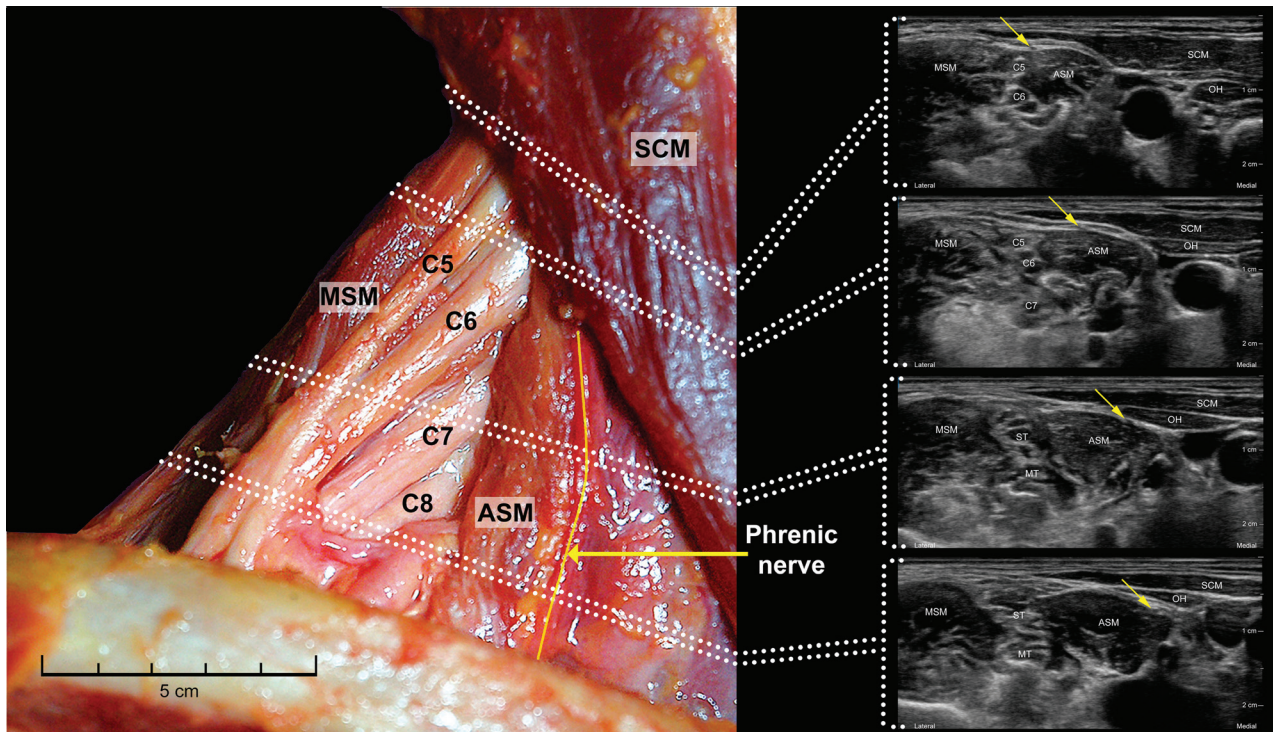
Cadaveric (*left*) and corresponding sonographic images (*right*) demonstrating the course of the right phrenic nerve as it emerges beneath the lateral margin of the sternocleidomastoid muscle (SCM), between the middle scalene muscle (MSM) and the anterior scalene muscle (ASM). It begins near to the roots of the brachial plexus, then travels inferomedially away from the brachial plexus. The C5–C7 roots of the brachial plexus emerge deep to the ASM, coursing laterally, where C5 and C6 roots merge to form the superior trunk. The sonographic images of the right interscalene area descending sequentially caudally, with the brachial plexus found between the MSM and the ASM. In the *upper image*, the phrenic nerve (*yellow arrow*) can be seen above (superficial to) the ASM in close proximity to the C5 nerve root. More caudally, the phrenic nerve (*yellow arrow*) can be seen to travel medially over the ASM and beneath the omohyoid (OH) muscle until it lies nearly 2 cm away from the brachial plexus. MT = middle trunk; ST = superior trunk. *Left image* adapted with permission from Danilo Jankovic and reproduced with permission from Ultrasound for Regional Anesthesia (USRA; <http://www.usra.ca>).
